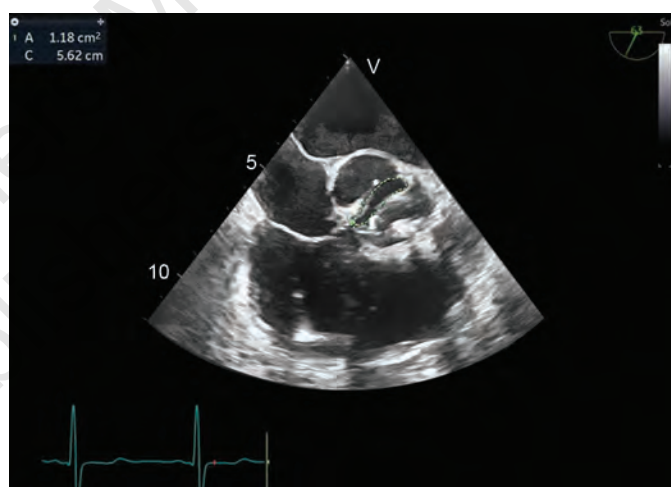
Measurement of aortic valve area by planimetry during transesophageal echocardiography.
